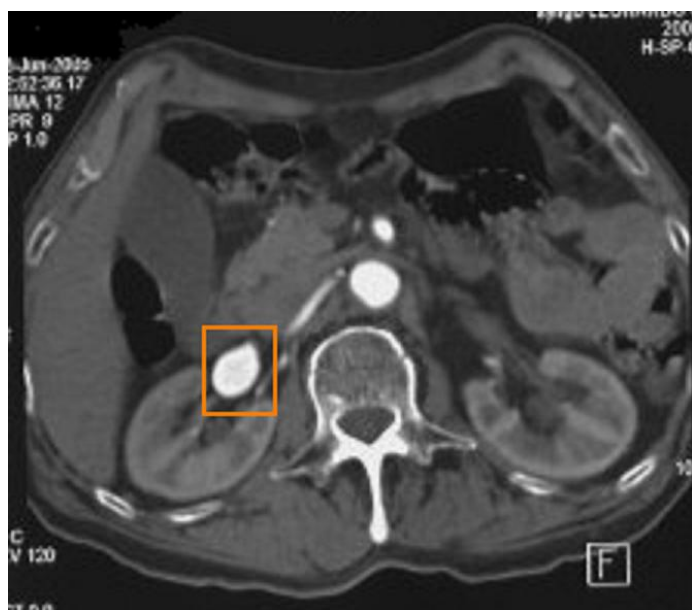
Axial image of contrast computed tomography of a 77-year-old male with hypertension showing an oval right renal artery aneurysm measuring 2.5cm in diameter (highlighted by orange rectangle).
